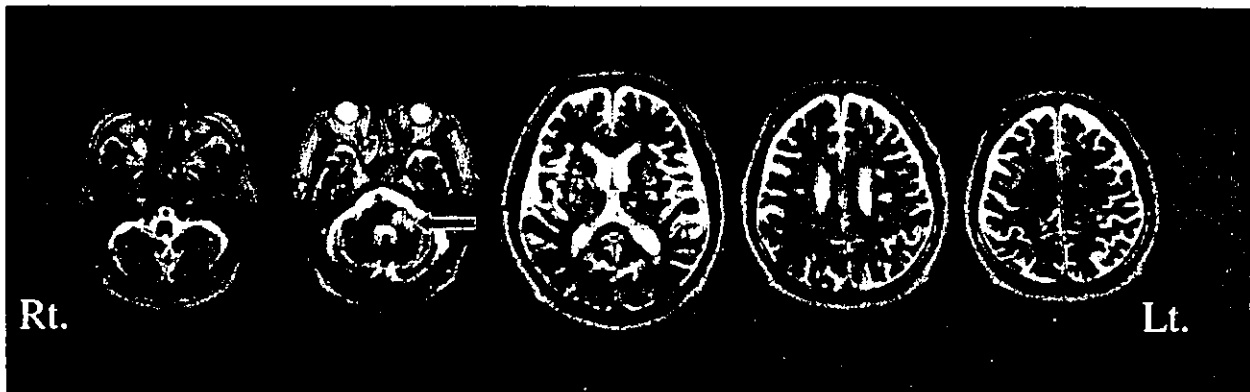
MR images obtained 24 days after symptom onset show an infarct strictly confined to the left middle cerebellar peduncle (arrow). No definite infarctions are visible in the cerebral hemisphere or the left cerebellar hemisphere on T2-weighted images. Rt., right; Lt., left.
